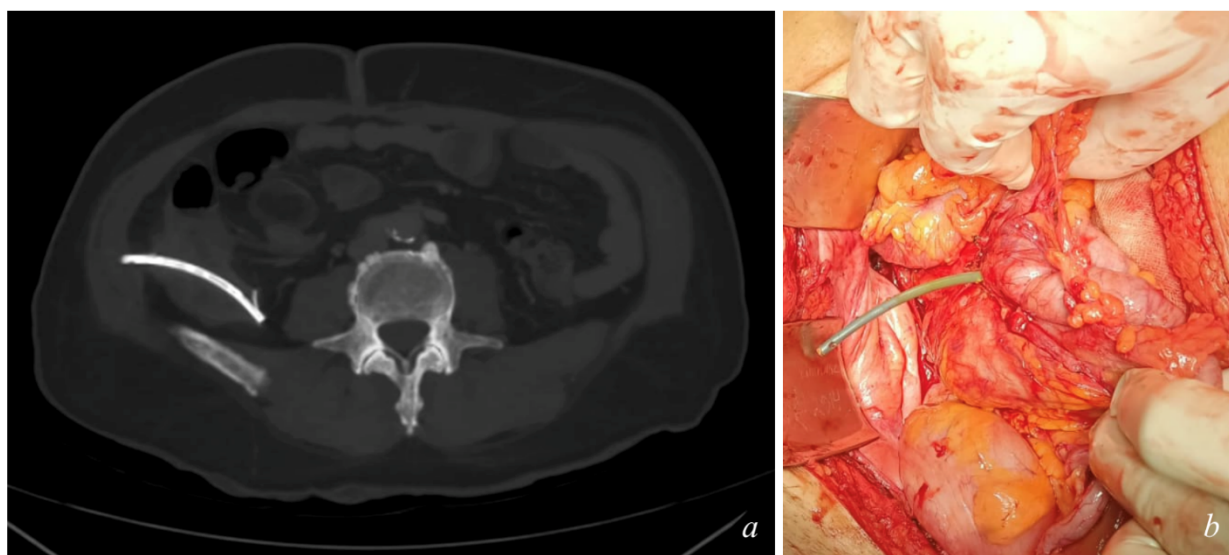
A. Contrast enhanced computed tomography (CE-CT) scan. Biliary stent migration with perforation of the ascending colon on its antimesenteric edge, contacting the abdominal wall. B. Ascending colon perforation due to biliary plastic stent migration.
